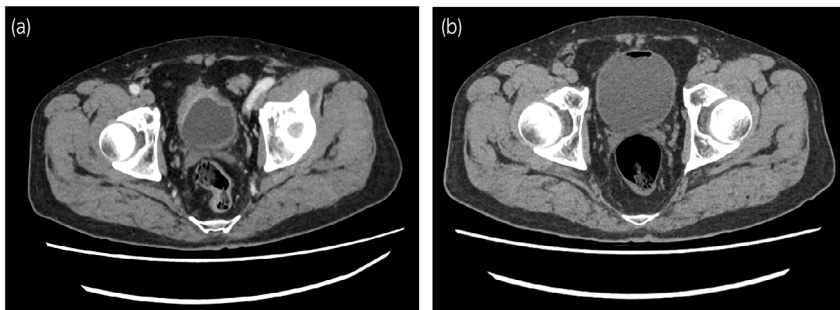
(a) CT images before steroid therapy. (b) CT images after steroid therapy.
